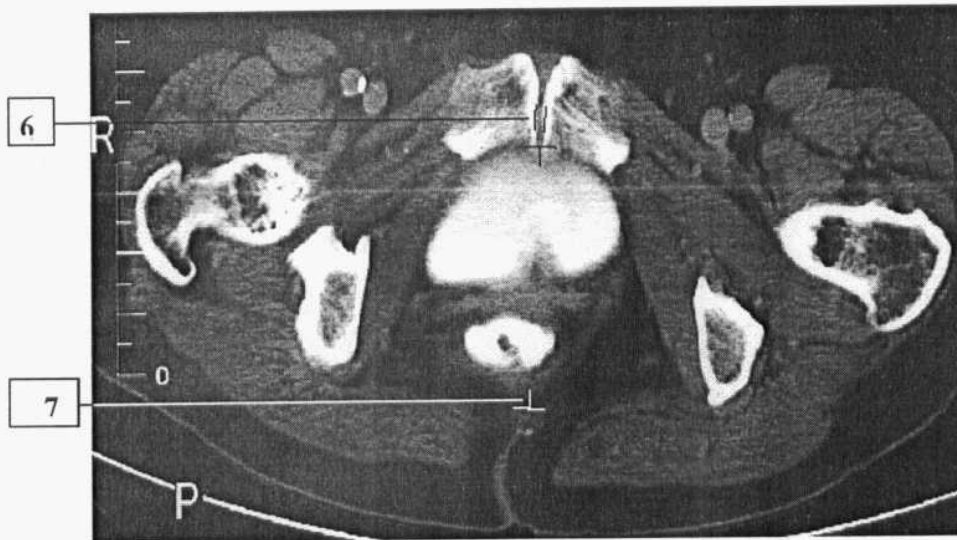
Normal axial CT anatomy of female pelvis
